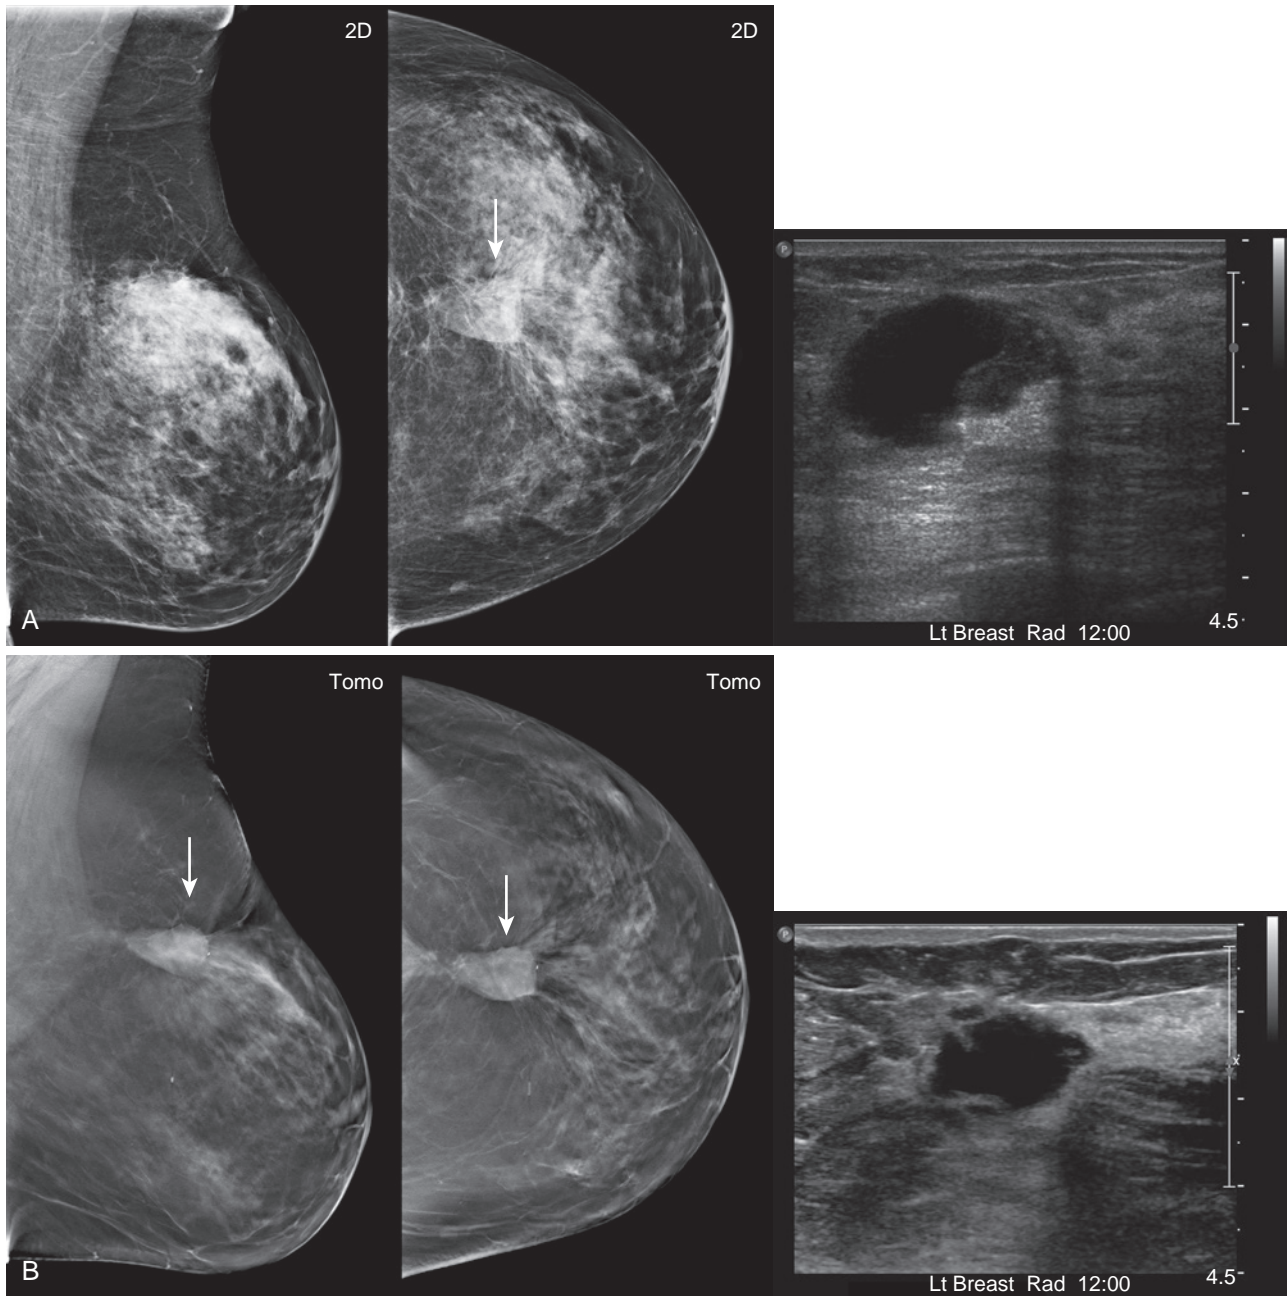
Seroma. (A) A mammogram following lumpectomy and accelerated partial-breast radiotherapy for stage 1 invasive ductal carcinoma shows an obscured oval seroma at the operative site (*arrow*). By ultrasound, the seroma is circumscribed, oval, and predominately anechoic with enhanced through transmission. (B) Ten years later, and well seen with tomosynthesis (*arrows*), the seroma is only slightly smaller.
